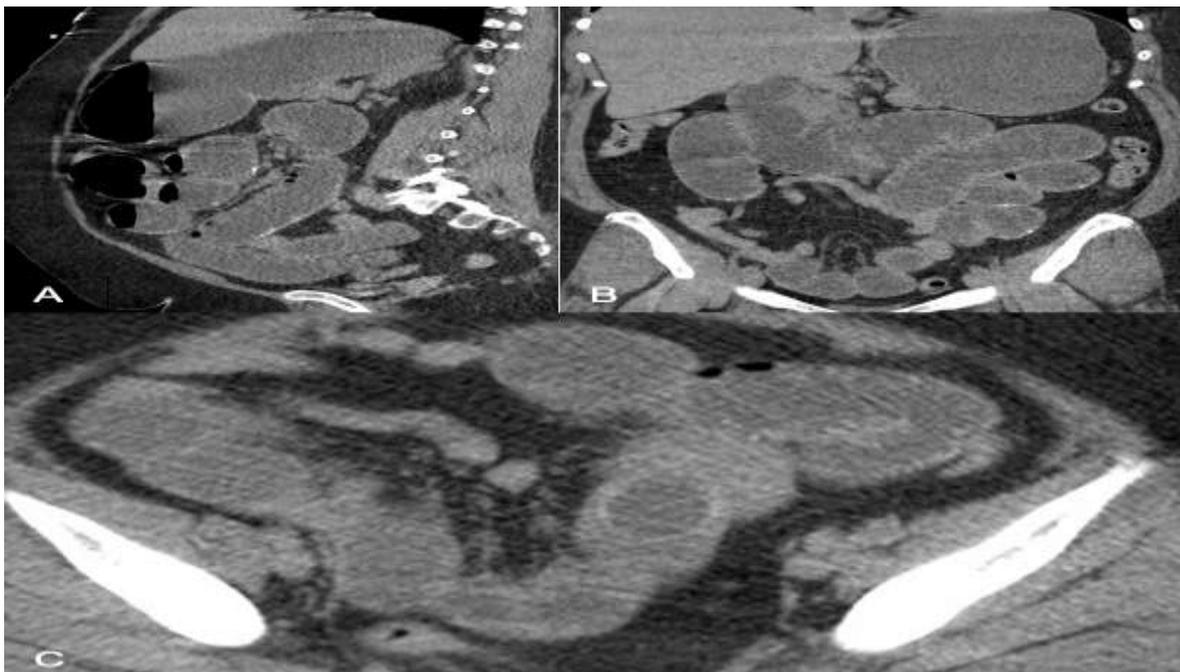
A: CT Sagittal view, multiple dilated loops of bowel and air fluid level. B: CT coronal view, C: CT, Axial view gallstone located in terminal ileum
